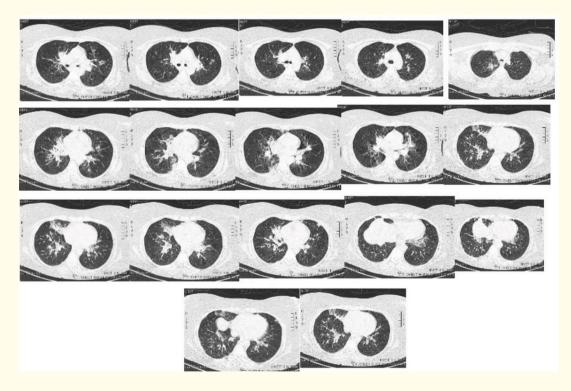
High resolution CT chest.
